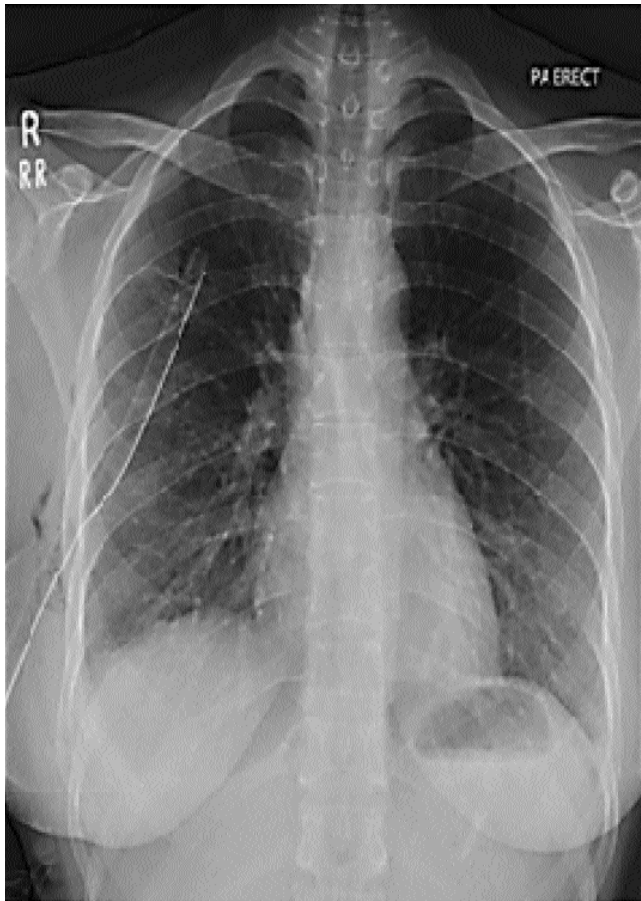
Chest X-ray showing drainage pipe.
